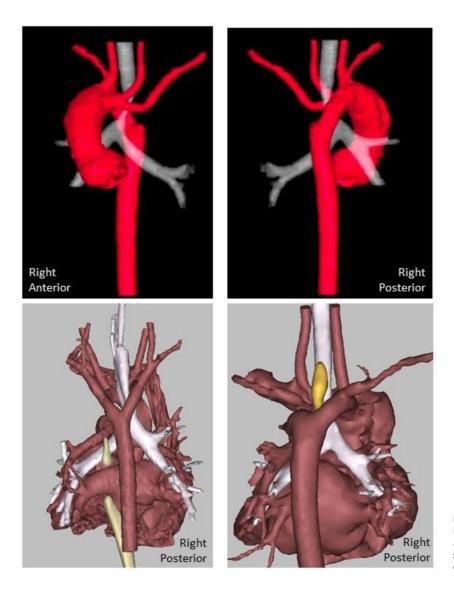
Three-dimensional reconstruction cardiac CT images in a patient with double aortic arch causing significant tracheal and esophageal compression. Vessels and cardiac structures shown in red, airway shown in white, and parts of the esophagus can be seen in yellow.
